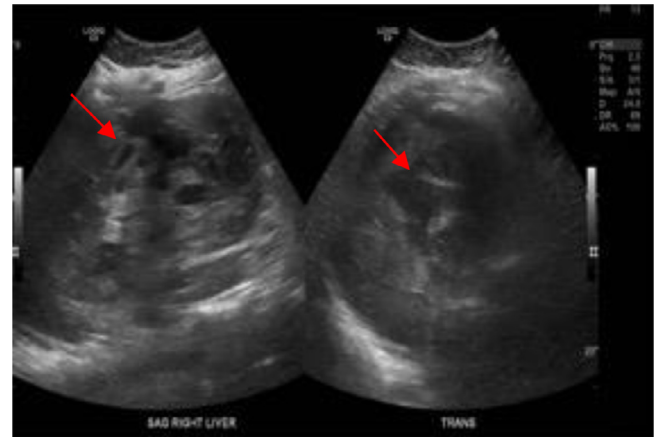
RUQ ultrasound showing complex solid-cystic mass within the right lobe of the liver (red arrows). No evidence of internal blood flow sonographically.
